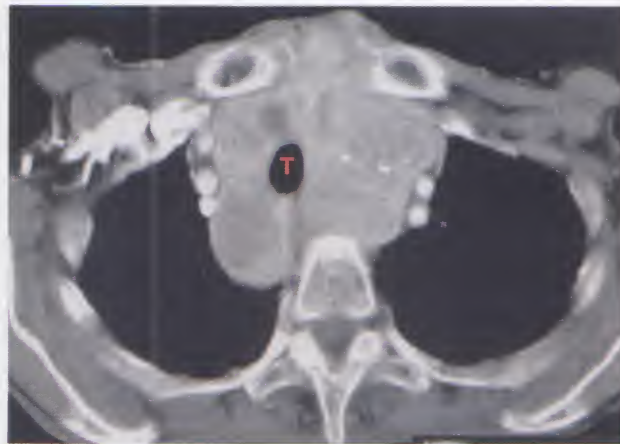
CT chest. The thyroid gland is considerably enlarged with retrosternal extension and deviation of the trachea to the right (T)
